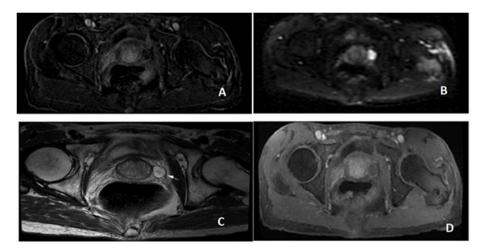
Presence of a left latero-prostatic formation with a mass effect on sectors 10a and 10p of the homolateral peripheral zone, classified as PIRADS 3 on MRI.
